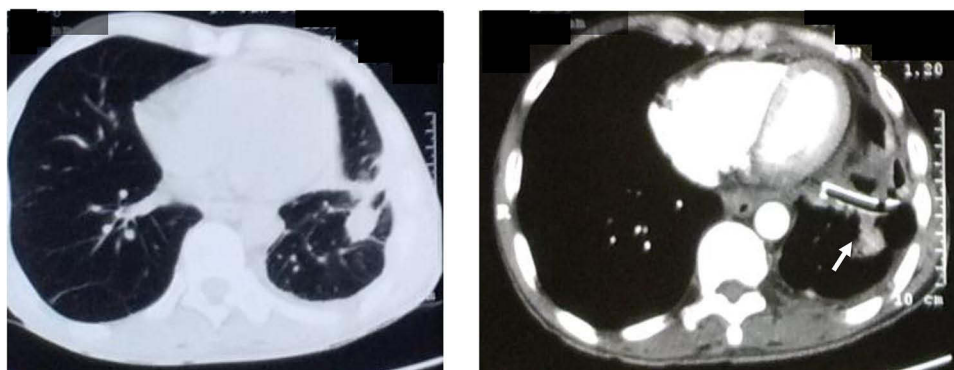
CT-scan imaging 02 months postoperative (54 year old patient): Reduced left lung volume, chest tube in the left side (white arrow).
